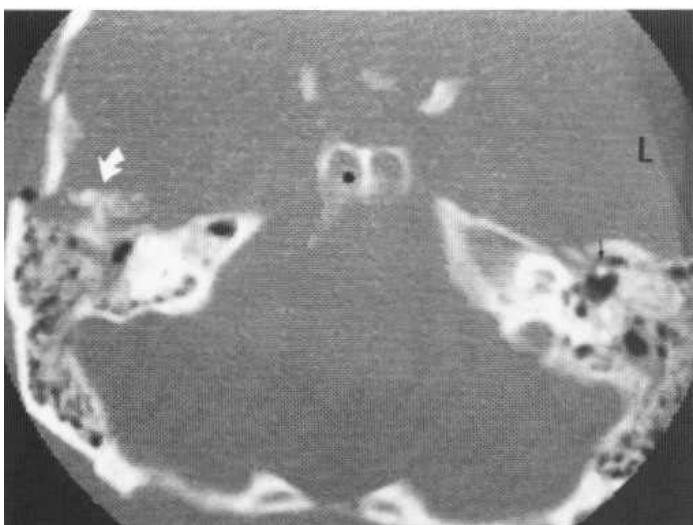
Longitudinal fracture of the petrous temporal bone with a depressed fragment of squamous temporal. The fracture line runs along the roof of the external meatus and middle ear with a small fragment of bone in the region of the genicular ganglion (white arrow). The fracture passed through the sphenoid sinuses which are filled (asterisk). On the left side the black arrow indicates the malleus in normal position; the incus was displaced. Axial CT scan.
